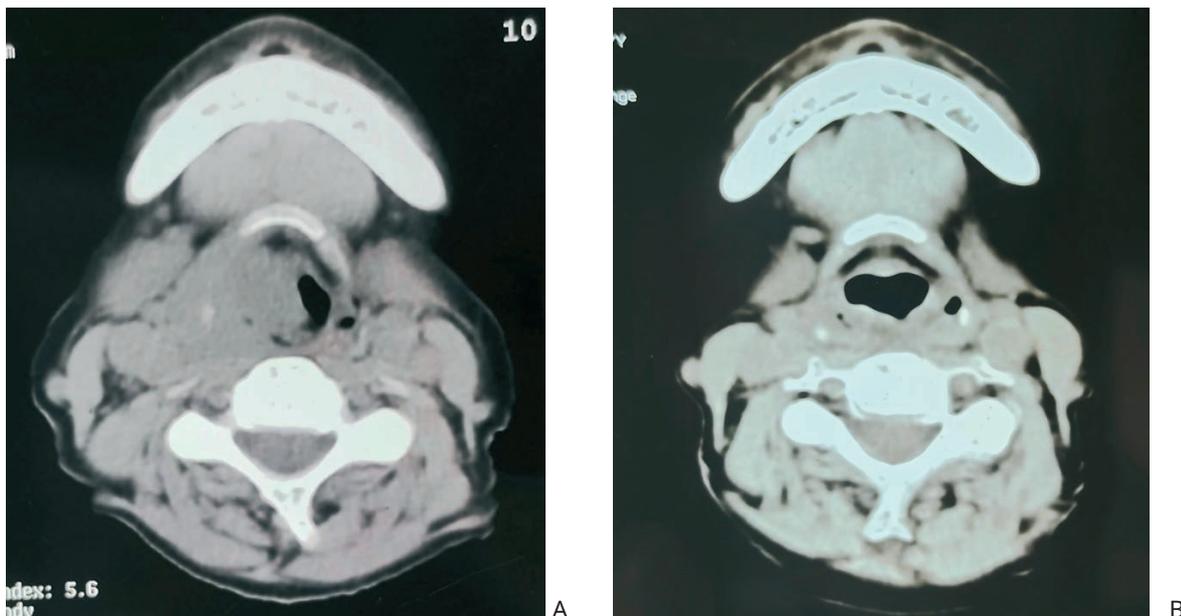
(A) Axial CT image of neck showing extensive pyriform fossa mass; (B) Response in the same patient in 6 weeks after completion of treatment.
